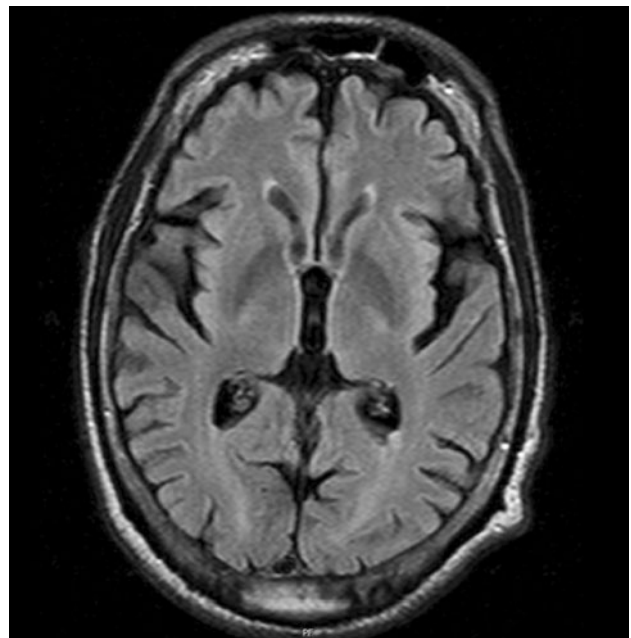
Brain MRI for Patient 1. Flair imaging demonstrated global atrophy but no leukoencephalopathy
